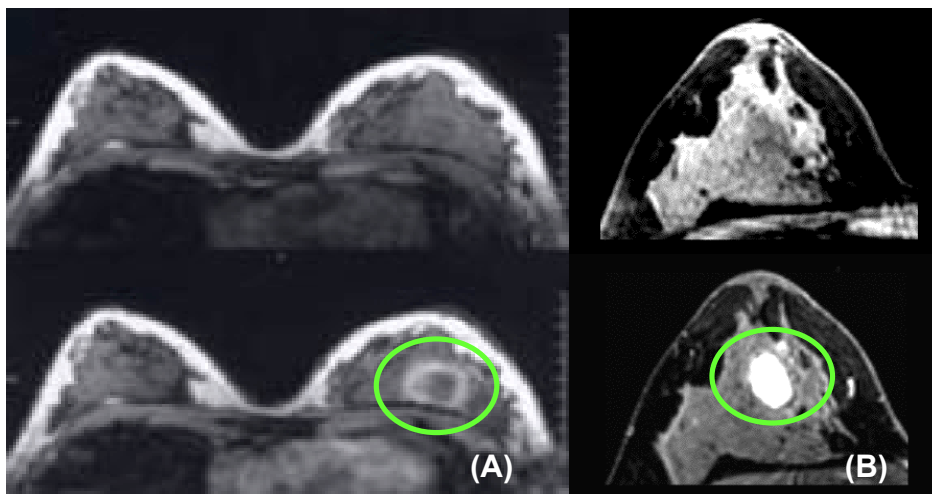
(A) Transverse fast acquisition breast MRI images at same level without contrast (upper) and with contrast (lower). The anomalies, emphasized by the green circles, show how the abnormality in the lower breast image on the right is "highlighted" by the contrast agent (gadolinium DTPA or Magnevist). (B) MRI scans of breast without (upper) and with (lower) contrast agent (Magnevist).¹⁹⁷
